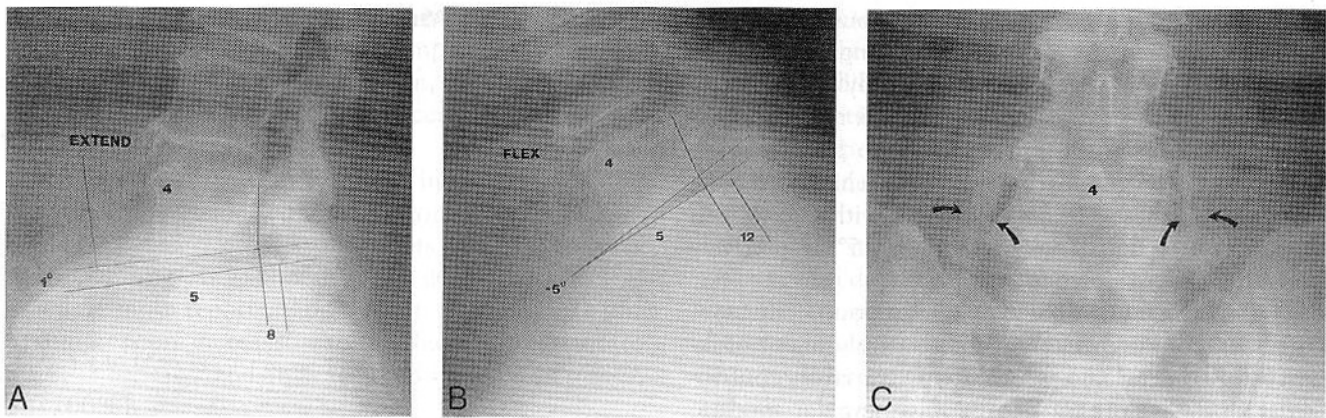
A, Two-year postoperative lateral extension radiograph demonstrating 8 mm of subluxation at L4–L5. B, Two-year postoperative lateral radiograph demonstrating an increase of the subluxation to 12 mm during flexion. C, Two-year postoperative anteroposterior radiograph demonstrating clefts (arrows) in the lateral fusion mass between L4 and L5.
